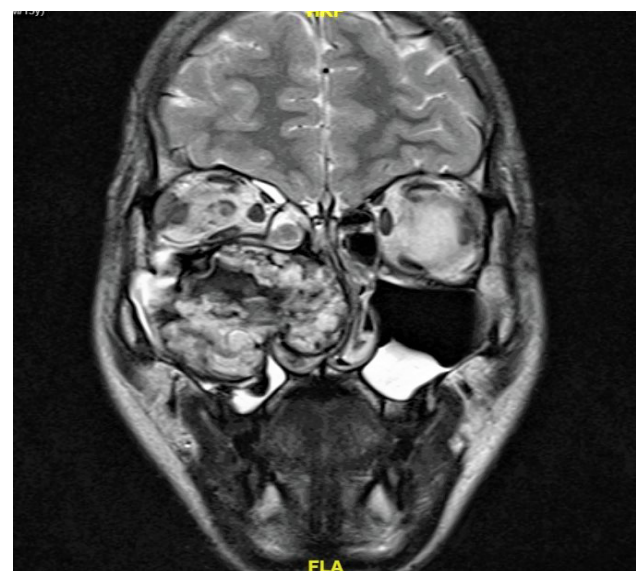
A T2-weighted coronal magnetic resonance imaging showed superior and lateral displacement of the right orbital contents
